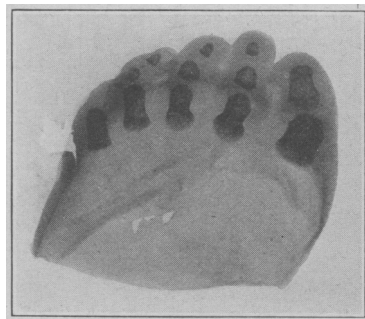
Print from a roentgenogram to show separation of phalanges from foot.
